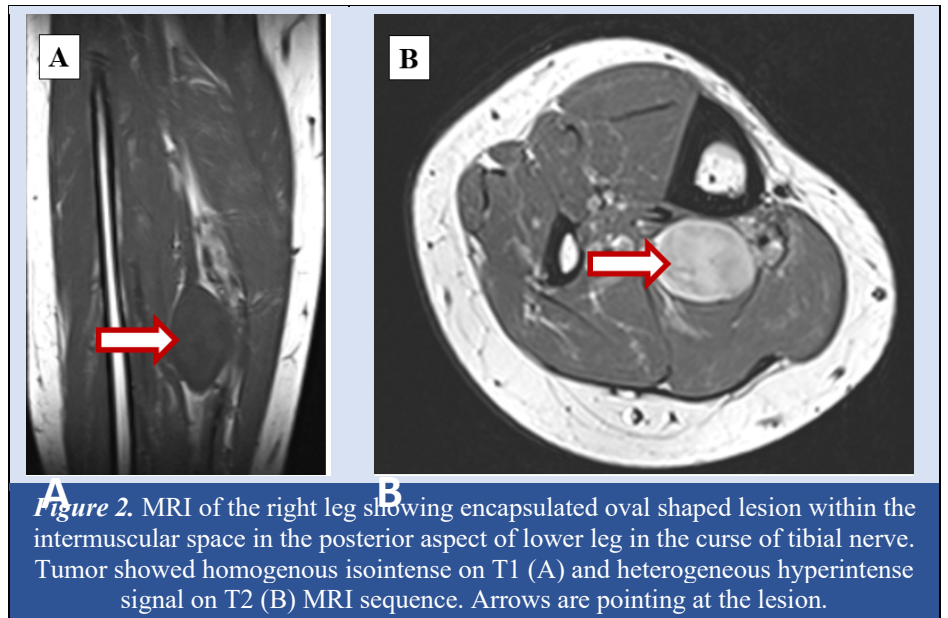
MRI of the right leg showing encapsulated oval shaped lesion within the intermuscular space in the posterior aspect of lower leg in the course of tibial nerve. Tumor showed homogenous isointense on T1 (A) and heterogeneous hyperintense signal on T2 (B) MRI sequence. Arrows are pointing at the lesion.
